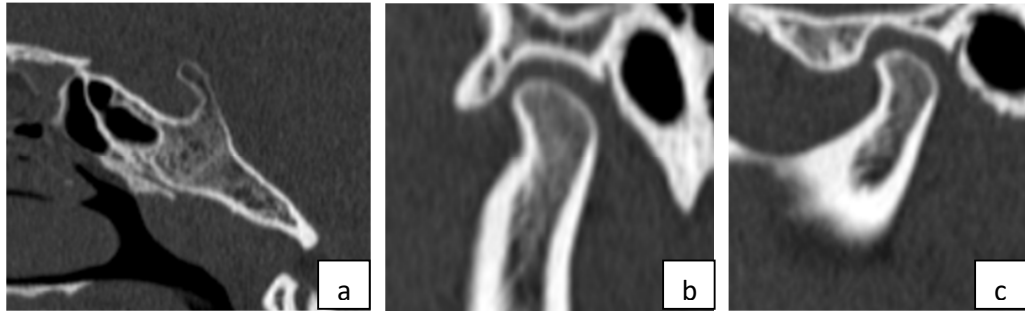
CT images of a 17-year-old male revealing a) Stage 2 of Spheno-occipital synchondrosis; b) Type II Condylar cortication on right side; c) Type II Condylar cortication on left side
